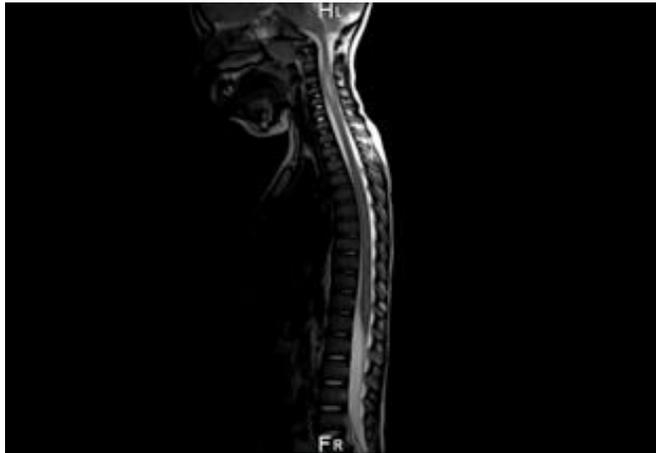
Patient's MRI of spinal cord T2 weighted image sample
